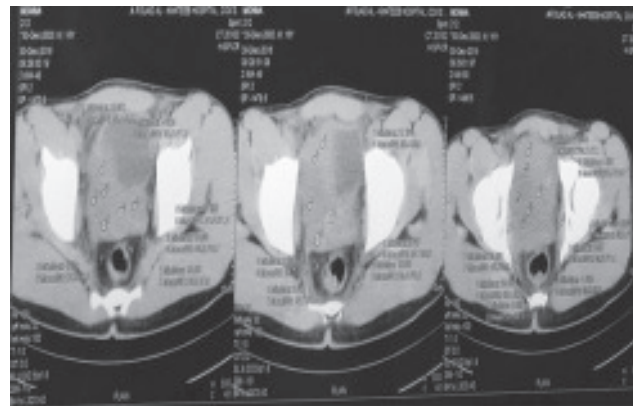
CT scan of abdomen showed a heterogenous enhancing mass lesion arising in the prostate
